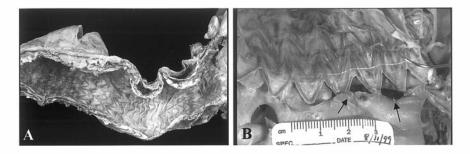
A 76-year-old man with multiple stent grafts in the arch, thoracic, and abdominal aorta implanted 61 days prior to sudden death following severe chest pain. After implanting three stent grafts, a CT scan showed an endoleak 6 days later. This leak was repaired with an additional endograft and a repeat CT scan 11 days later was unremarkable. At autopsy, there was an aortic dissection extending proximally resulting in a hemopericardium. A tear was identified at the proximal end of the stent graft near the junction of the normal aorta (arrows in A and B).
